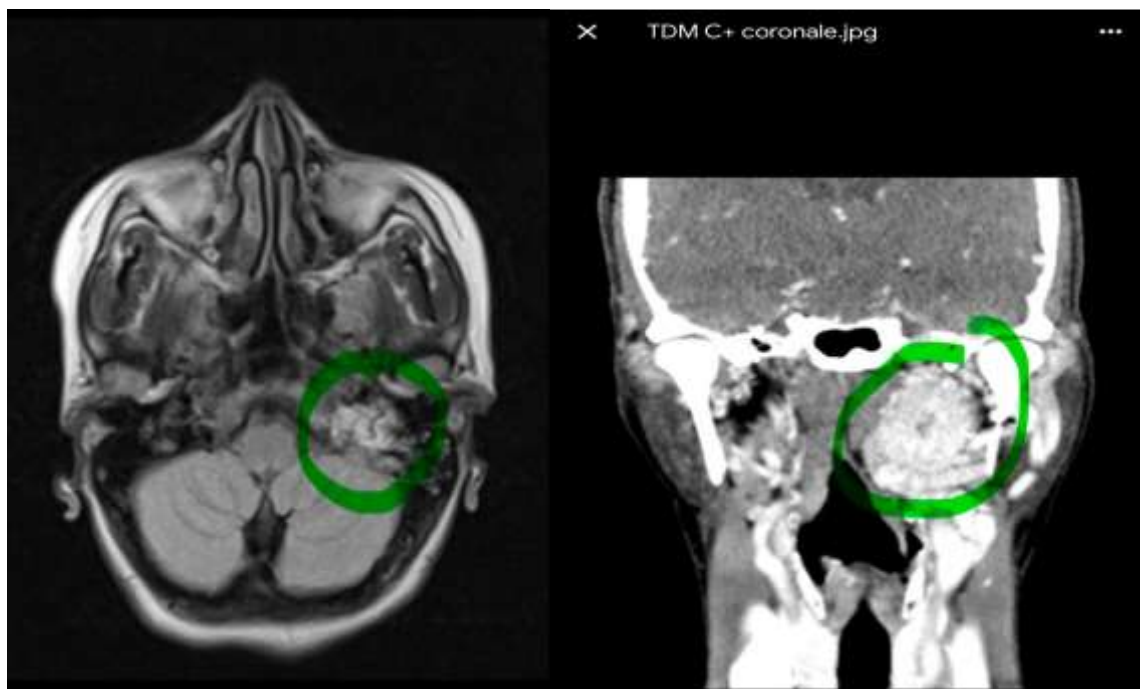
expansive process at the left jugular foramen , CT scan and MRI images
